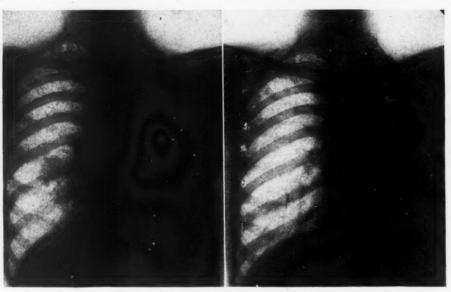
Very chronic pleural and pulmonary changes in left thorax and earlier changes near right root. Plaintiff claimed injury to lower left ribs was cause of lung condition. Roentgen study within six weeks of accident.
